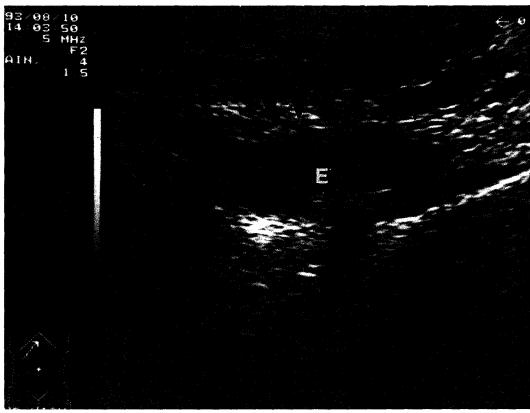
Ultrasonographic evidence of effusion within the pseudocapsule in patients treated with resection arthroplasty. The echopattern was echofree. 12 ml of effusion were aspirated and were sterile. (E- effusion. black arrows - pseudocapsule).
